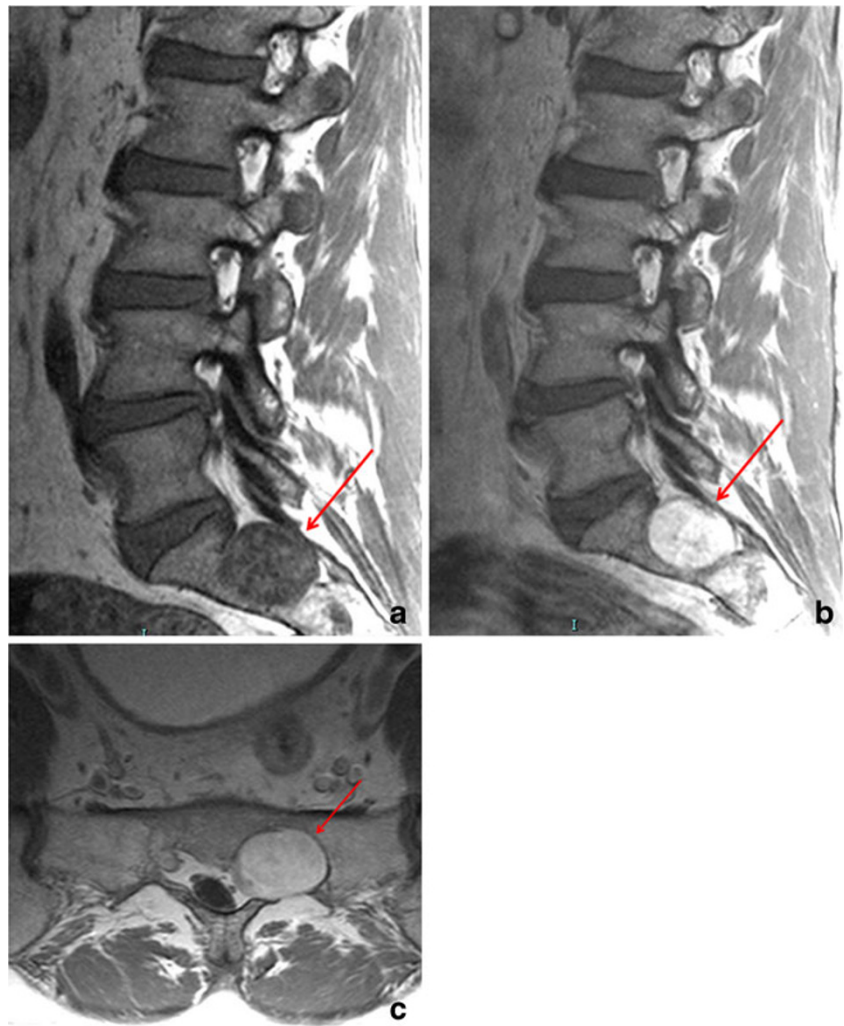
a, b MR images of a psammomatous melanotic schwannoma of the spine in a patient with CNC (*red arrows*). c Axial T2-weighted image of the spine shows a mass lesion with intermediate signal intensity and “dumbbell” morphology causing enlargement of the intravertebral foramina (*red arrow*)
